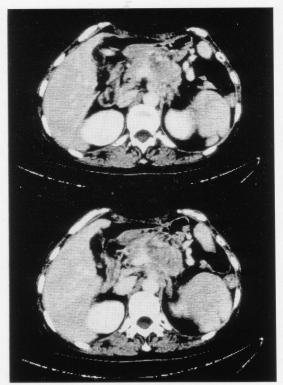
X-ray CT images of the advanced pancreatic body cancer. An invasive large mass is identified in the pancreatic body and tail region.
